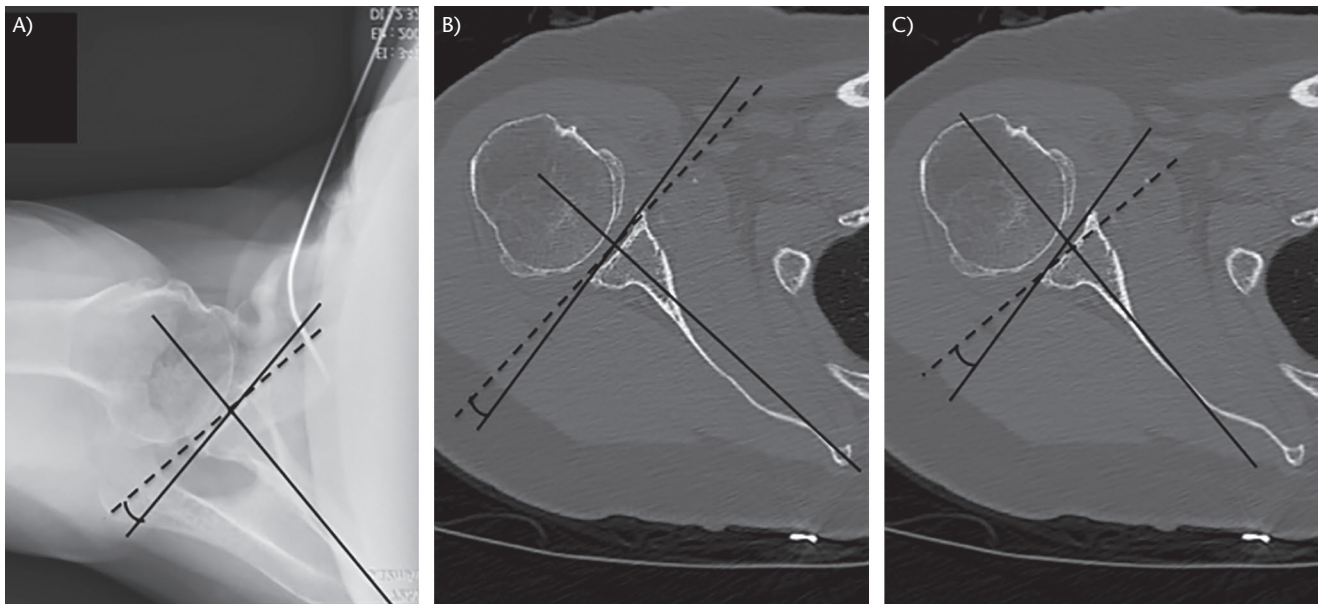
(A) Glenoid version as measured on an axillary right shoulder radiograph using the Friedman method, where version is the angle between the glenoid line and the perpendicular (dashed) to the line joining the medial edge of the scapula and the centre of the glenoid (scapular axis). (B) Glenoid version as measured on axial CT using the Friedman method, where version is the angle between the glenoid line and the perpendicular (dashed) to the line joining the medial edge of the scapula and the centre of the glenoid (scapular axis). (C) Glenoid version as measured on axial CT using the glenoid hull method, where version is measured in a similar way to the Friedman method, but with the glenoid hull plane (the line between the centre of the glenoid and the point of the scapula where the anterior and posterior cortices meet medially) replacing the scapular axis.
